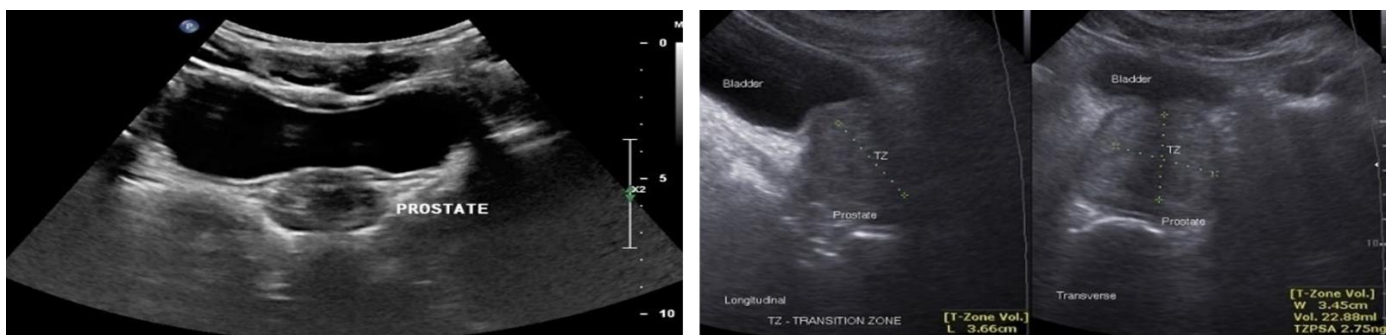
Transabdominal ultrasound images of the prostate gland: axial, longitudinal, and transverse views.
